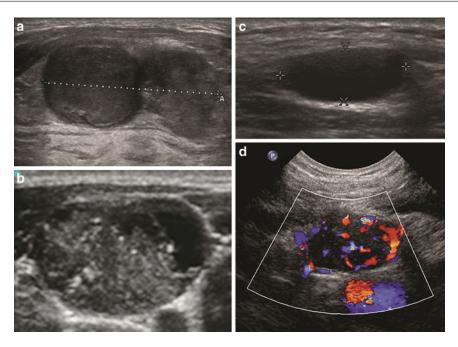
Ultrasound features of malignant lymph nodes. (a) Rounded, matted lymph nodes with metastatic papillary thyroid cancer. (b) Punctate calcifications, rounded shape, and partial cystic replacement seen in a lymph
